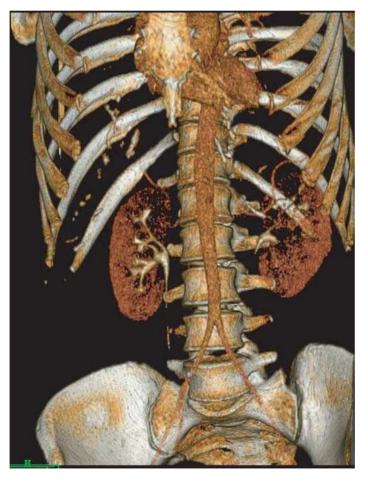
Volume rendering of a CT angiography study showing bones, vessels, and enhanced organs. The study was performed on a Philips Brilliance 40 CT scanner.
